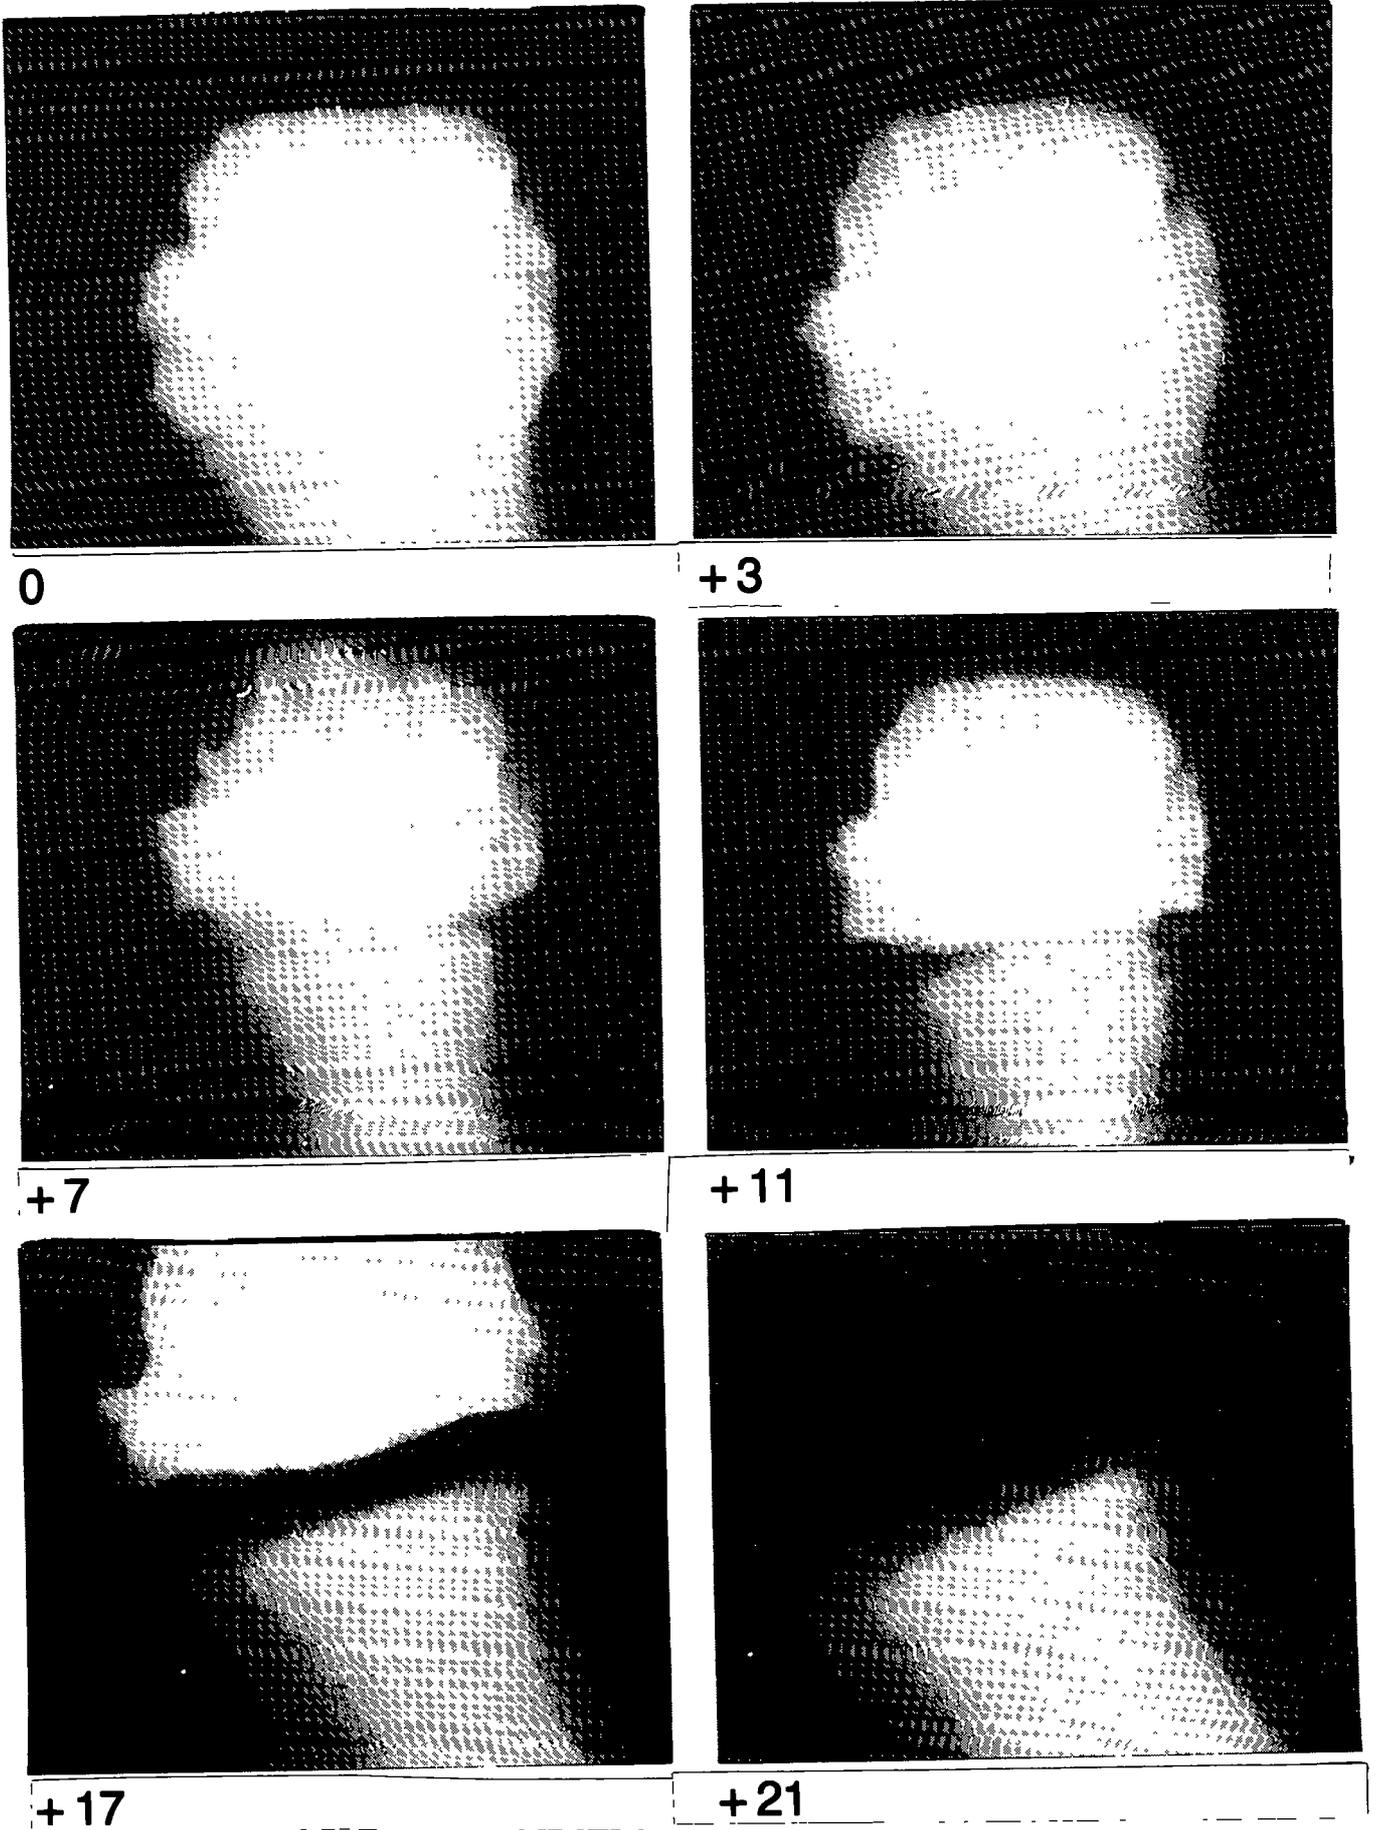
Serial radiographs taken (0, 3, 7, 11, 17 and 21 days) between castration and had antler casting in one typical stag.
